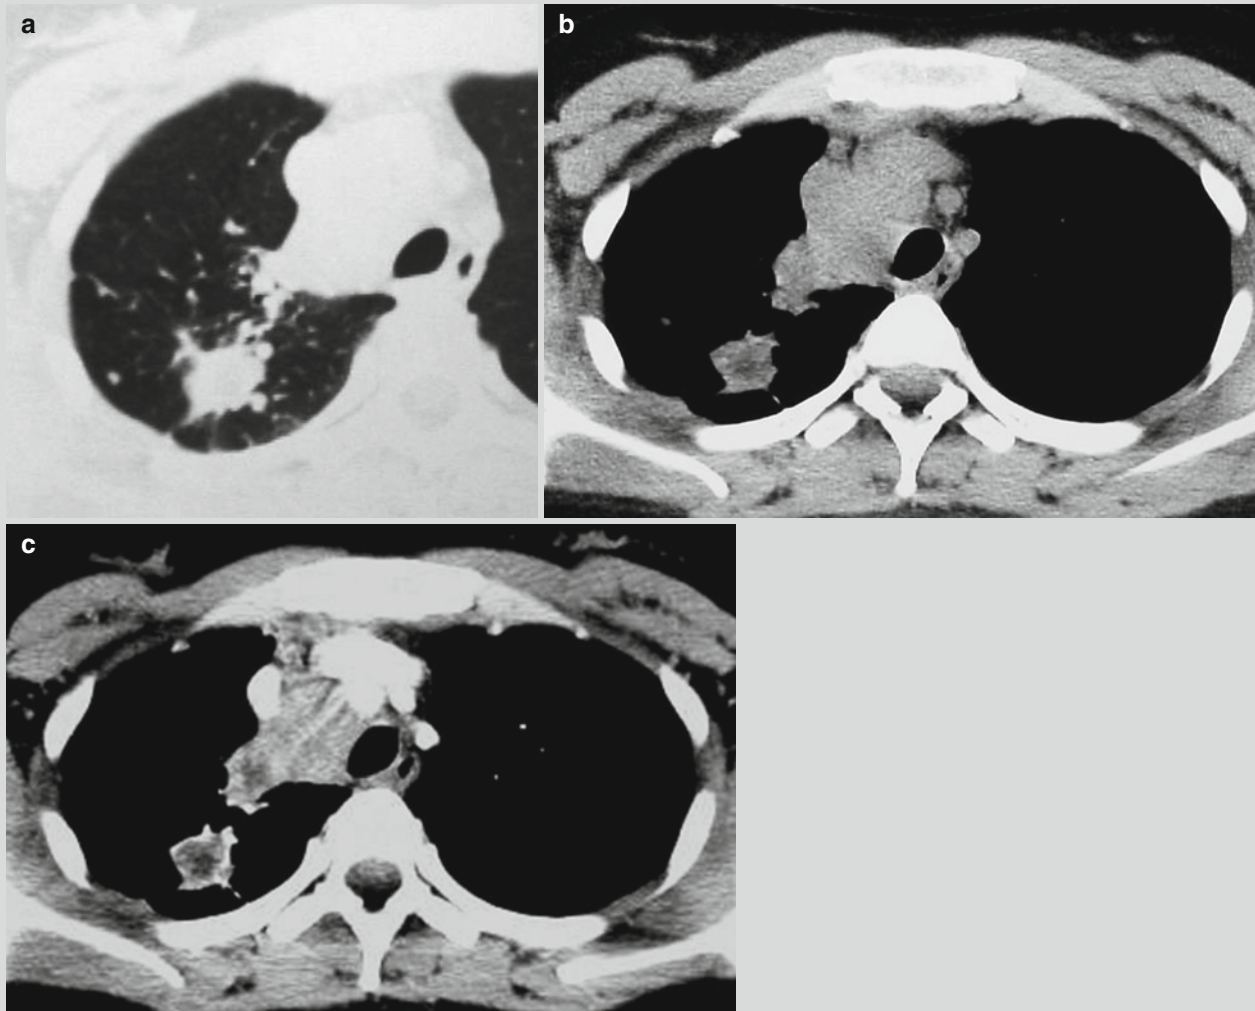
Primary syndrome. (a) CT scanning demonstrates irregular nodular shadows at the apical segment of the right upper lobe, surrounding spot- and cord-like shadows, and flakes of shadows near mediastinum that connect to the mediastinum. (b) CT scanning demonstrates uneven density of the nodules at the right upper lobe, low-density area in the parenchyma, lymphadenectasis at the 2R
